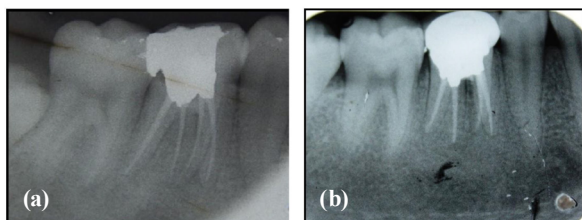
(a) Immediate post obturation radiograph (b) A two year follow up radiograph
